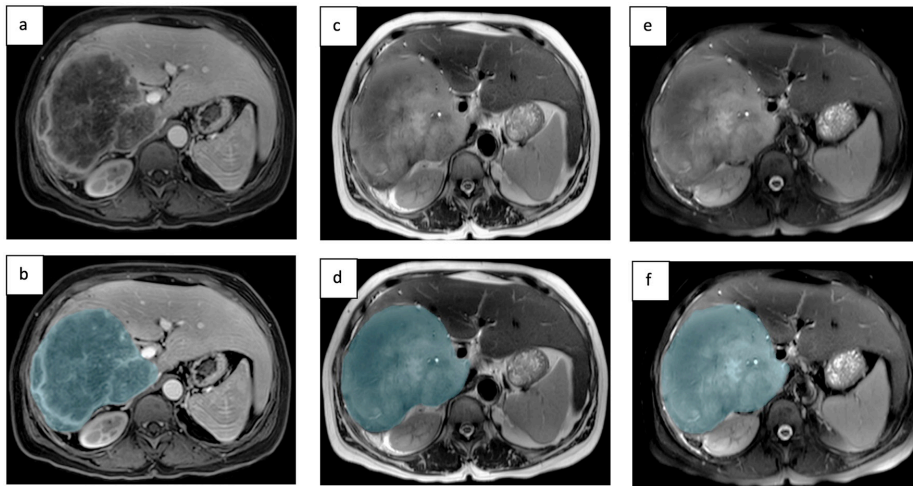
A 58-year-old male patient had pathologically proven intrahepatic cholangiocarcinoma in the entire right lobe of the liver. Segmentation of this mass was performed on axial T1-weighted contrast-enhanced equilibrium phase (a, b), axial T2-weighted sequence without fat suppression (c, d), and axial T2-weighted with fat suppression (e, f) magnetic resonance images.
